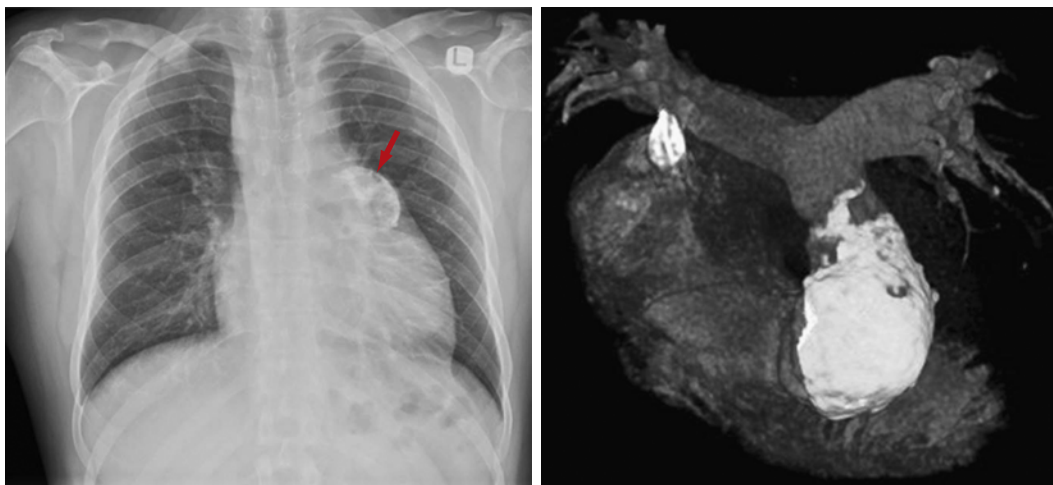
On the left, a preoperative chest x-ray of the patient described in Fig. 11.2: severe calcification of the right outflow tract, indicated by the red arrow, is obvious. The three-dimensional-computed tomography reconstruction (on the right) shows the magnitude of calcification that extended into the main pulmonary artery.
